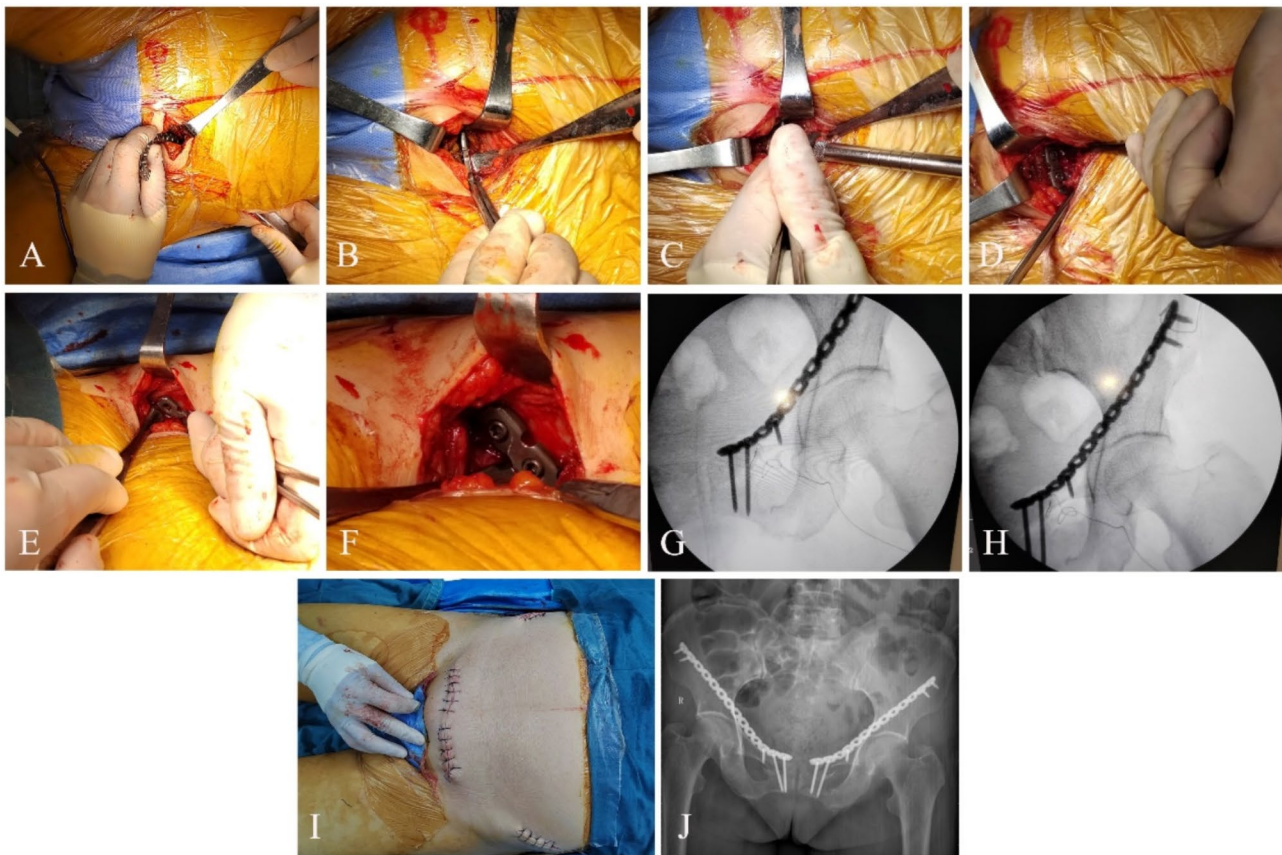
A, B: Subperiosteal insertion of shaped steel plate on top of the pubic rami aligned from the acetabular anterior wall to the inner table of the iliac crest by flexing the ipsilateral hip and knee. C-F: After reduction, depth sounding and screw placement (Zone I of Nakatani classification) were performed in the medial and lateral incision. The steel plate's downward pressure force and the upward pull force of screws contributed to further fixation and reduction of the fracture. G, H: Intraoperative radiographs showed the displaced fracture was satisfactorily restored. Use of a similar surgical approach to fixate the right pubic ramus. The sacral fracture was conservatively treated because the posterior pelvis was stable after the anterior ring fixation. I: Suture the wound layer by layer. J: postsurgical AP pelvic radiograph showed a satisfactory fracture reduction
